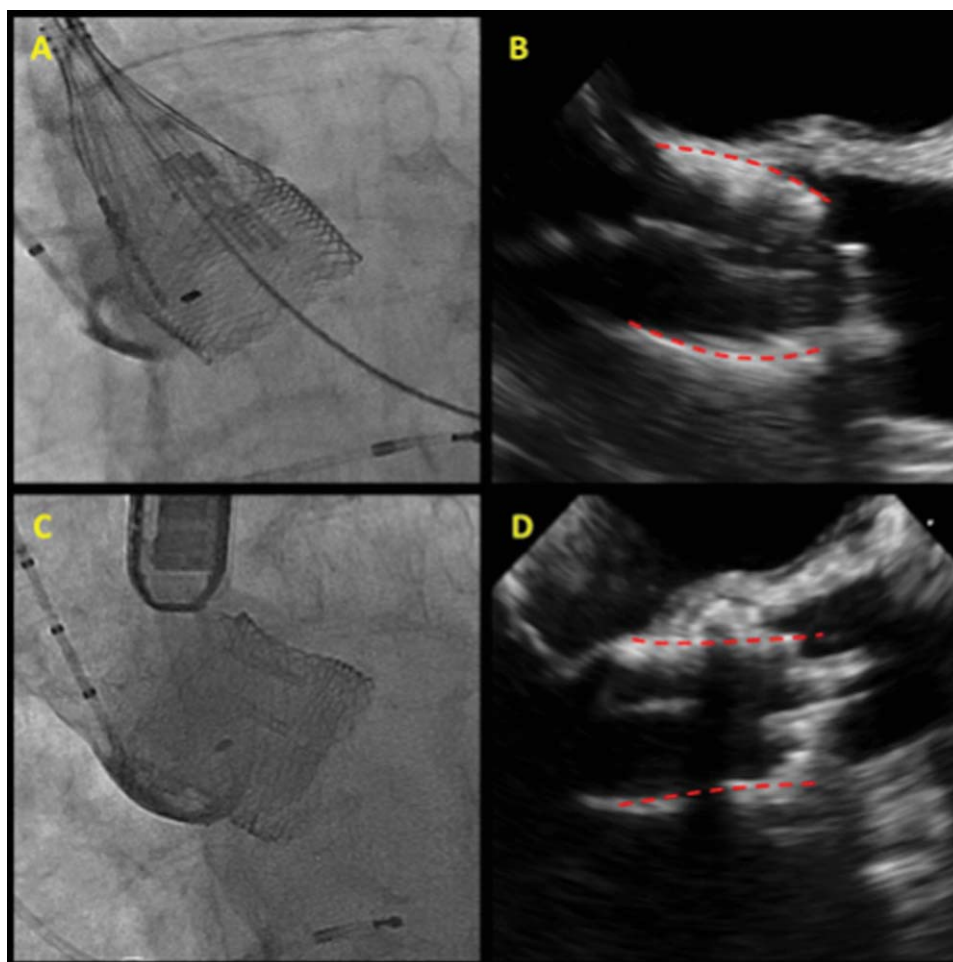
Fluoroscopic and echocardiographic assessment. A: Fluoroscopy showing no waist on the locked 23 mm Lotus prosthesis. B: A similar barrel shaped appearance was seen on TEE. (Prosthesis highlighted by red dashed line). C: The locked 27 mm prosthesis showing a slight waist at the annular level. D: A similar appearance is seen on TEE. (Prosthesis highlighted by red dashed line).
